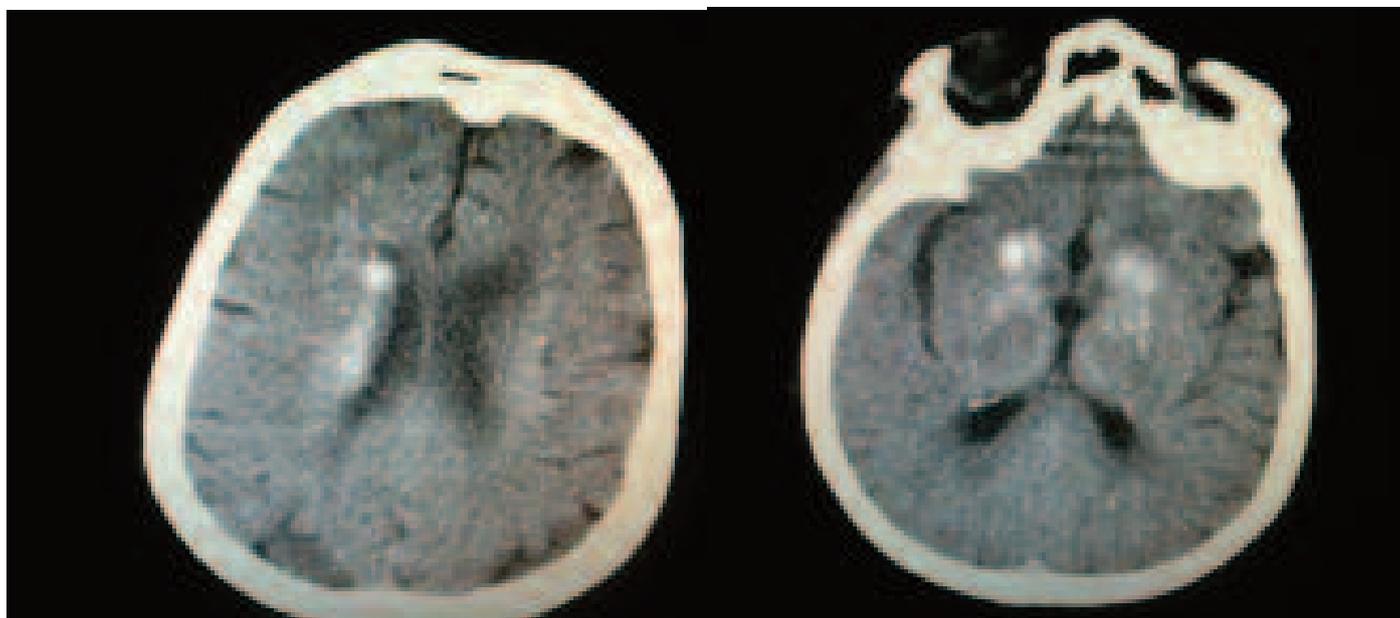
CT scans of patient 1, showing symmetrical calcifications on the bilateral cerebellar hemispheres, at the bulbar and periventricular levels, the bilateral internal capsule and caudate nucleus and on both sides at the level of the centrum semiovale.
